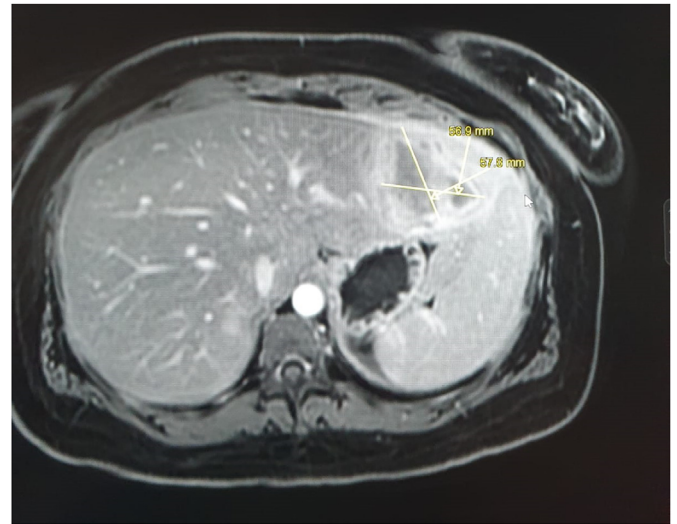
Liver MRI showing regression of the mass size.
